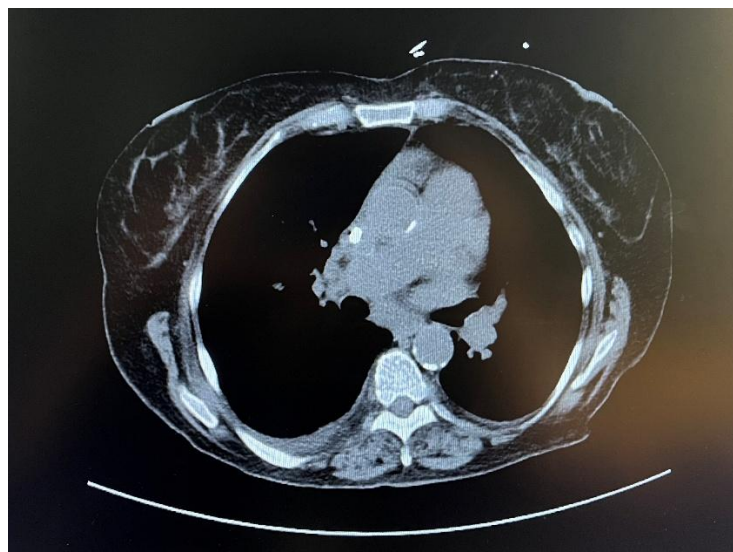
CT of the chest showing no pathologically enlarged lymph nodes.
